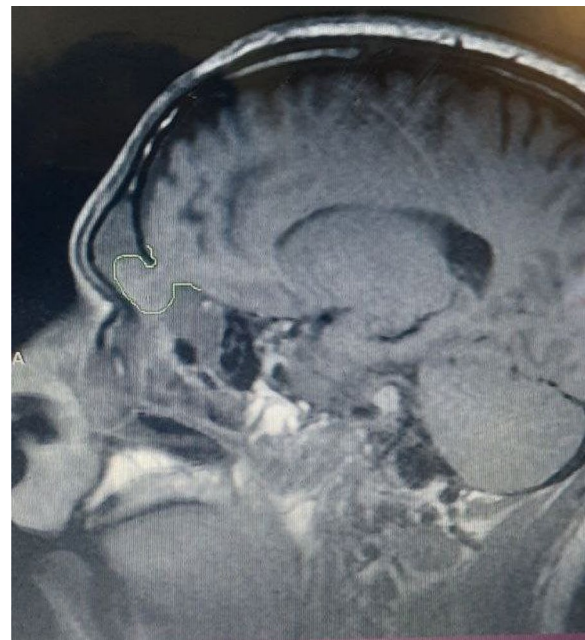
(Magnetic resonance imaging before surgery) magnetic resonance image of the sagittal plane shows an encephalocele in the nasal cavity. The brain tissues with the meninges herniate through the skull base fracture with a significant expansion of the subarachnoid spaces in the right hemisphere
